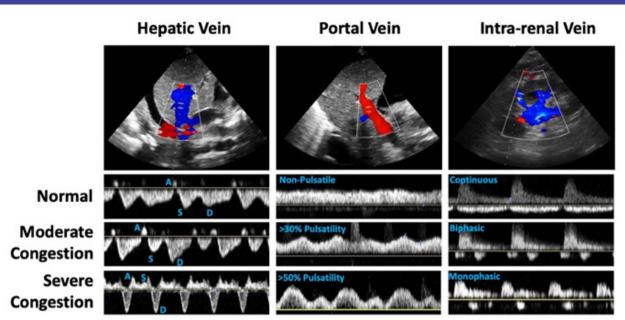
Doppler markers of venous congestion for the hepatic vein, porta vein and intrarenal veins.
